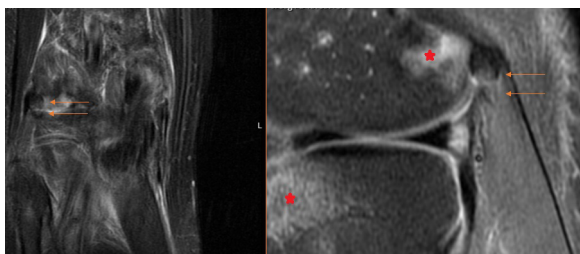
Magnetic resonance image of the fabella fracture (arrows) and tibial and femoral bone contusion (stars).
